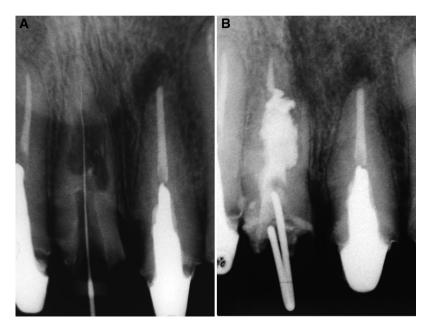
Endodontic retreatment of the right maxillary central incisor: (A) periapical radiograph showing the root canal negotiation; (B) radiographic image of the resorption lesion filled with MTA.
